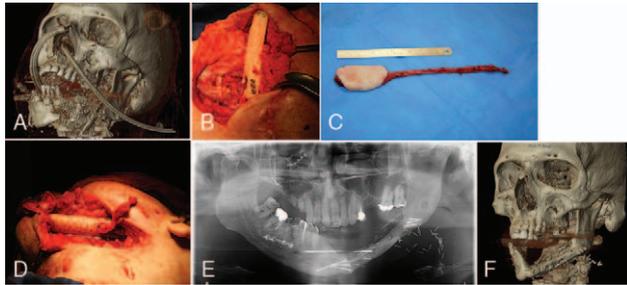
(A) Initial posttraumatic CT-scan 3D view. (B) Allograft in the mandibular defect. (C) Radial forearm flap. (D) Pedicle position of the flap through the allograft. (E) Postoperative orthopantomogram. (F) Postoperative CT-scan 3D view. CT, computed tomography; 3D, three-dimensional
